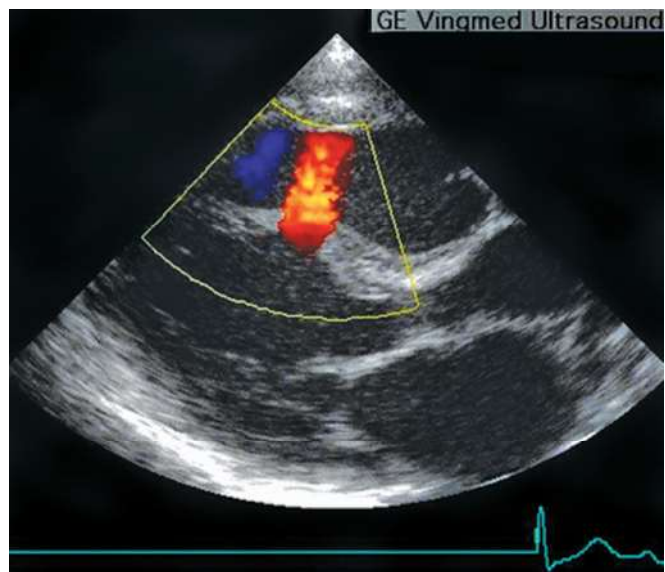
Colour flow Doppler echocardiogram demonstrating small mid-septal muscular ventricular septal defect
